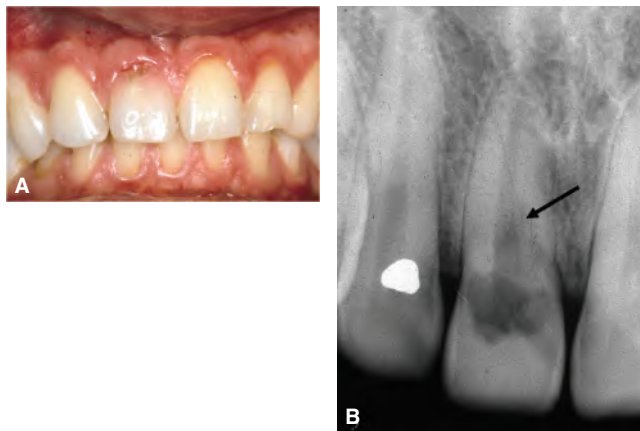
A. Cavitation of labial enamel with exposure of underlying resorptive tissue can be observed in the crown of the maxillary right central incisor, that also shows a pink discoloration. B. Radiograph of the tooth pictured in A shows an irregular radiolucency in the tooth crown and extending into the coronal third of the root (arrow). The pulp space is demarcated from the image of the resorptive lesion by a radio-opaque line. (Reproduced from Heithersay GS. *Quintessence Int.* 1999;30:27–37; used with permission from Quintessence Publishing.)
